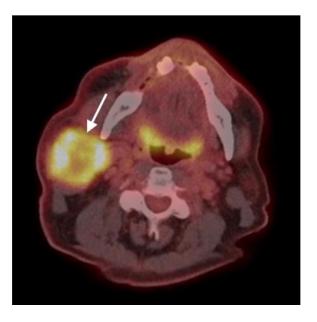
PET-CT image which exhibits exquisite hypermetabolism of the right parotid mass with central necrosis. No locoregional or distant metastases were evident on PET-CT.
